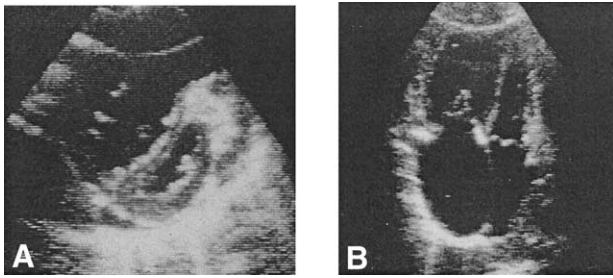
Echocardiogram: (A) Short axis view demonstrating right ventricular enlargement and flattening of the interventricular septum. (B) Four-chamber view demonstrating marked right atrial and right ventricular enlargement. The left heart chambers are small.
